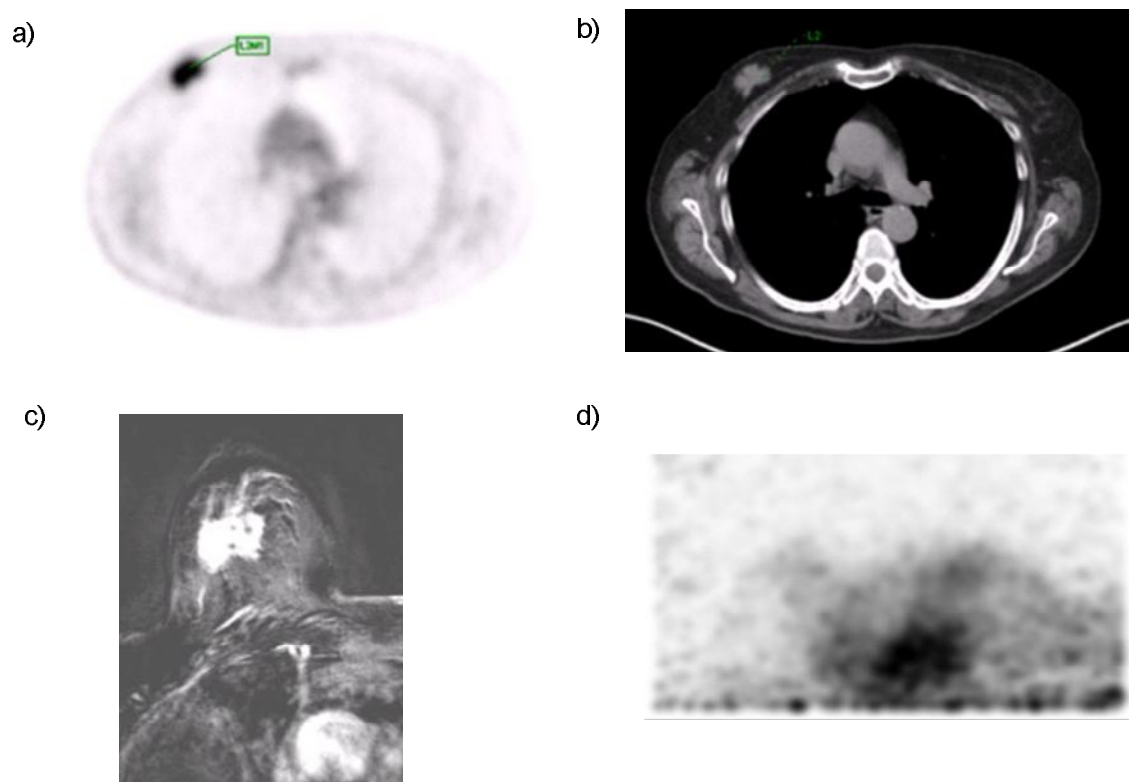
a) whole-body PET, b) CT, c) MRI of and d) ClearPEM of the right breast of case 2
